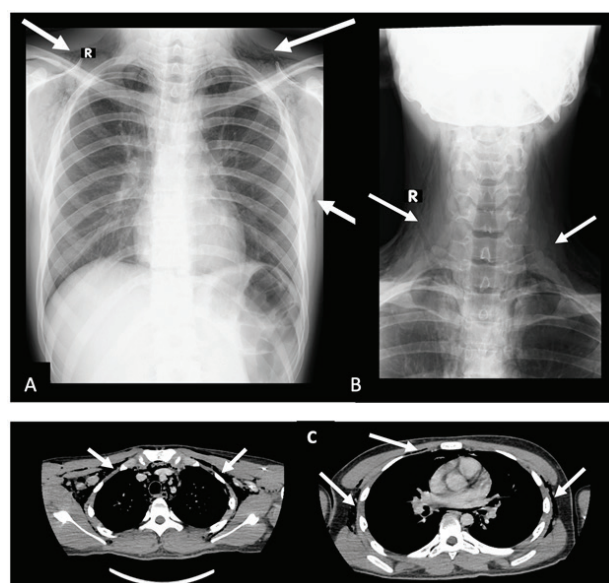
(A) Chest radiograph demonstrating cervical and thoracic subcutaneous emphysema (white arrows). (B) Neck radiograph showing extensive cervical soft tissue emphysema. (C) Contrast-enhanced CT chest demonstrating subcutaneous emphysema involving the cervical and thoracic fascial planes with associated pneumomediastinum (white arrows).
